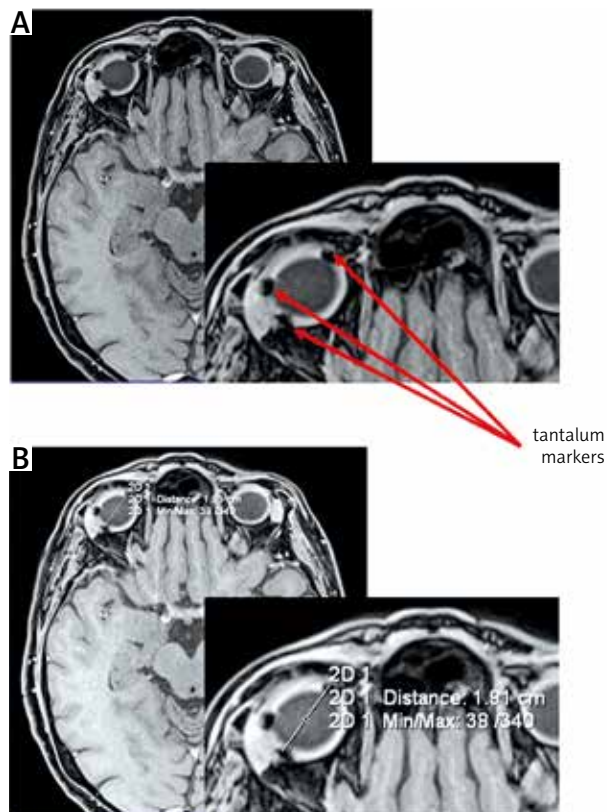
The example of verification (A) and measurement of distance (B) of markers using MRI
